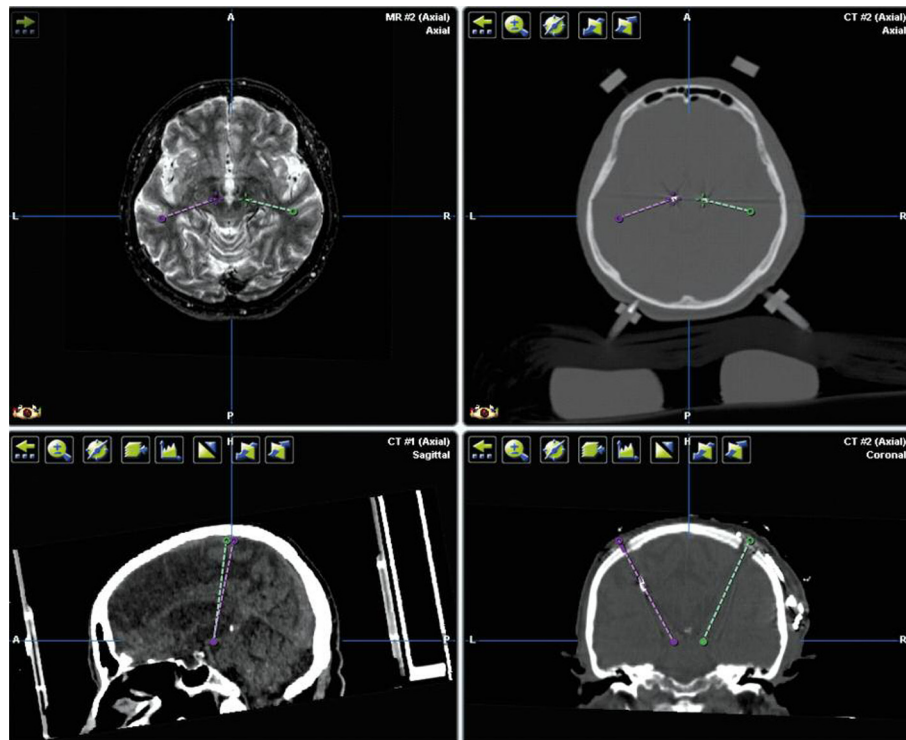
Fusion between intraoperative CT scan and MRI planning during deep brain stimulation
